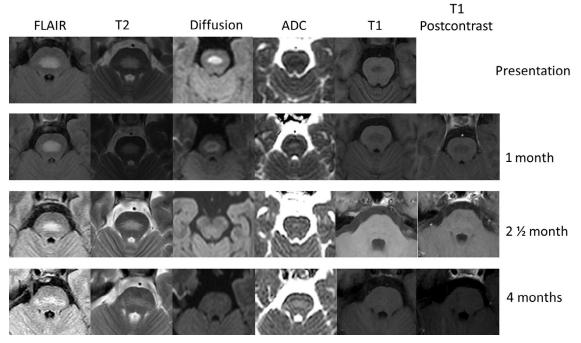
Paraneoplastic encephalopathy patient with a history of ovarian carcinoma presenting with encephalopathy with marked improvement in mental status following chemotherapy. (Row 1) At presentation, central pontine T2 hyperintense signal with restricted diffusion and T1 hypointensity. The "trident" or "bat wing" morphology of central pontine myelinolysis is absent, although the corticospinal tracts are spared. (Row 2) At 1-month follow-up, there is slight increase in extent of the T2 abnormality within the central pons with peripheral restricted diffusion and central T2 "shine-through" effect. No enhancement is seen. (Row 3) At 2.5-month follow-up, there is decrease in the size of the T2 hyperintense lesion. Restricted diffusion and T1 hypointensity have resolved. There is a small focus of elevated diffusion (hyperintense on the ADC map). No enhancement is seen. (Row 4) At 4-month follow-up, the T2 hyperintense lesion is smaller in the anterior posterior dimension but longer in the transverse dimension. There is increased facilitated diffusion. No abnormality is identified on T1-weighted images, and there is no abnormal enhancement.
